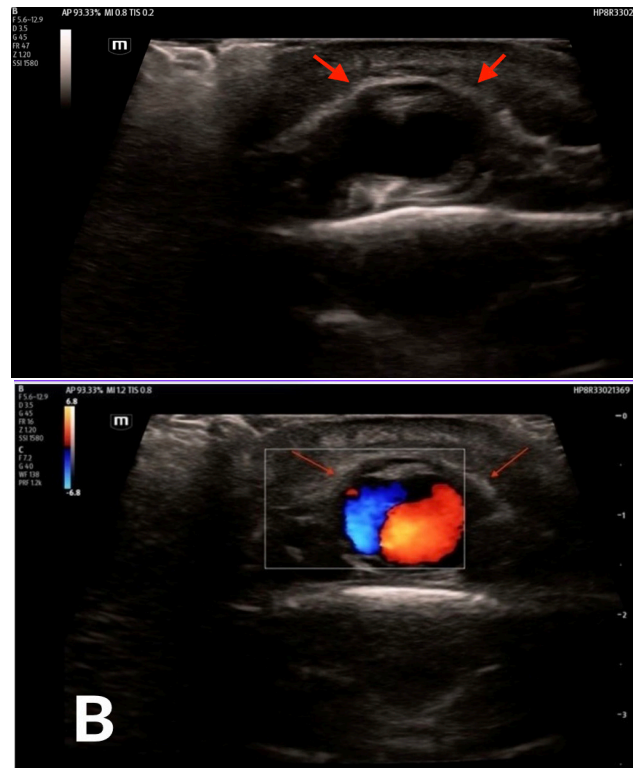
Point-of-care ultrasound (POCUS) gray-scale image using a linear probe demonstrates an anechoic, cystic structure (red arrowheads) adjacent to the occipital artery representing a pseudoaneurysm. Image 3B. POCUS image using a linear probe with color Doppler demonstrates turbulent flow with the characteristic yin-yang appearance within an anechoic, cystic structure (red arrowheads) adjacent to the occipital artery confirming the presence of a pseudoaneurysm.
